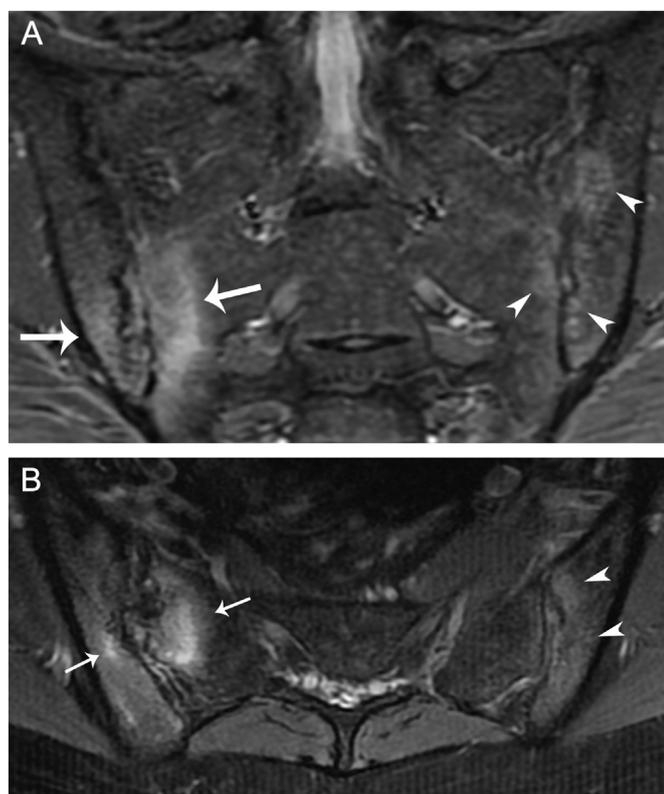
MRI findings of sacroiliitis. 29 year old female with HLA-B27 positive ankylosing spondylitis. A. Coronal oblique STIR and B. axial T2 fat saturations images show predominantly bilateral symmetric inflammatory lesions, including osteitis and erosions at the bilateral sacroiliac joints (white arrows).
